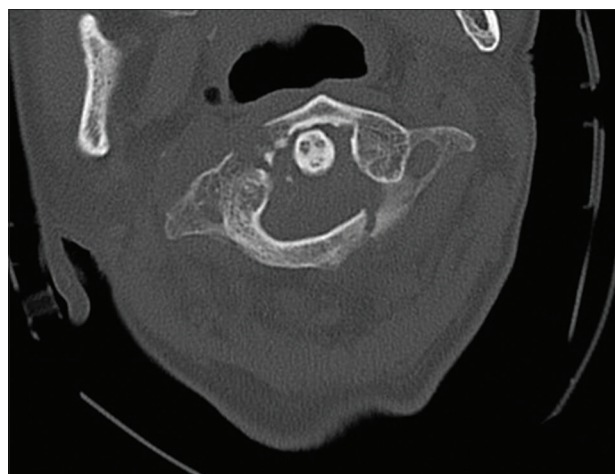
Preoperative cervical axial computed tomography scan demonstrating C1 fracture pattern of the anterior and posterior arches, involving also the right lateral mass.
